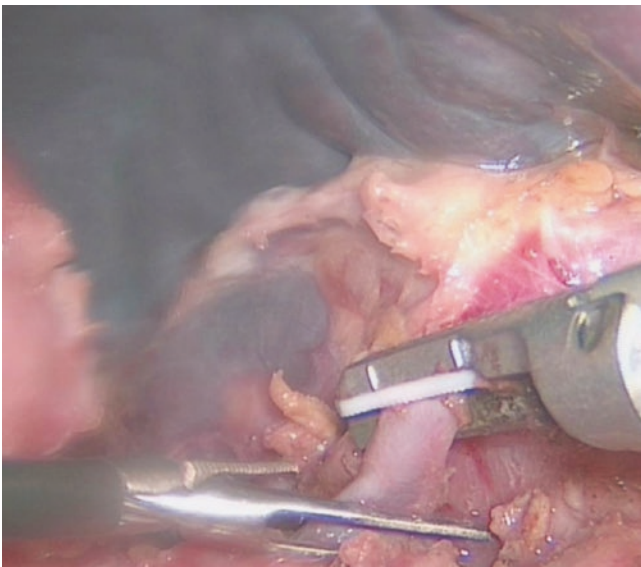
A “two step” approach with early sealing of the main splenic artery is recommended. This allows the spleen to empty and aids retrieval. The splenic artery is sealed using either a ligature of a braided material or 5-mm clips, e.g. Polyester locking clips. The artery can then be divided more distally with an ultrasonic or thermal fusion sealing device. Clipping of the vessels can cause problems if a stapler is subsequently used. If lower pole partial splenectomy is planned, the gastro-splenic vessels should be preserved
